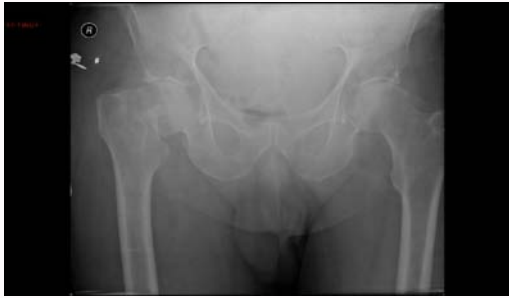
Pelvic radiograph showing displaced (Garden IV) right intra-capsular NOF fracture.
